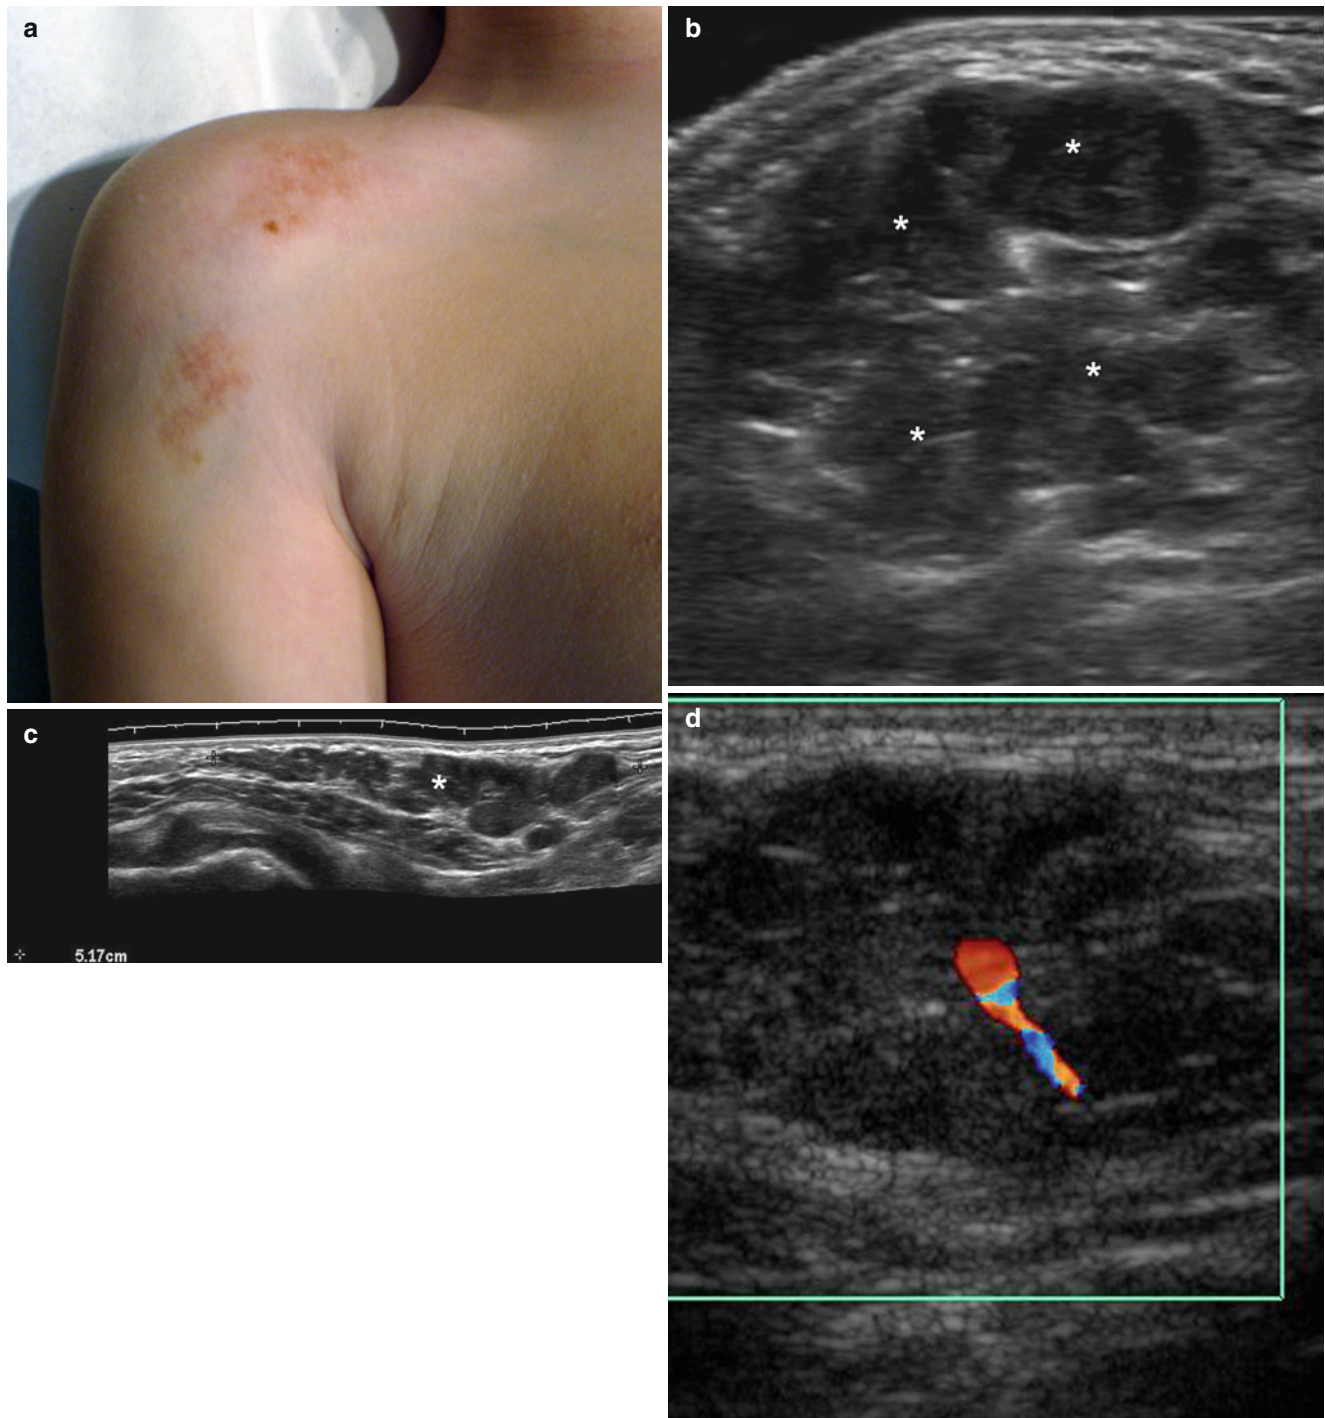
(a–d) Plexiform neurofibromatosis. (a) Clinical image shows café-au-lait spots in the right shoulder and arm. (b) Grey scale ultrasound image (transverse view, right shoulder region) demonstrates several and confluent hypoechoic nodules (*) in the subcutaneous tissue. (c) Grey scale ultrasound image (extended field of longitudinal
